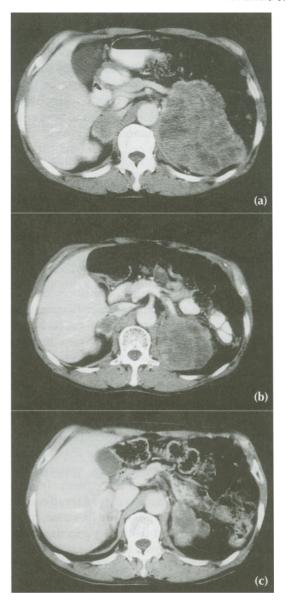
Contrast enhanced computed tomography scans of the patient described in case 2 before thermoradiotherapy (a), immediately after thermoradiotherapy (b), and 2 months after the therapy ended (c). During the therapy, the bilateral adrenal tumors shrank from 415 cm³ to 196 cm³ on the left side, and from 21.9 cm³ to 8.5 cm³ on the right side. Two months after the therapy ended, they decreased to 34.5 cm³, and 1.8 cm³, respectively.
